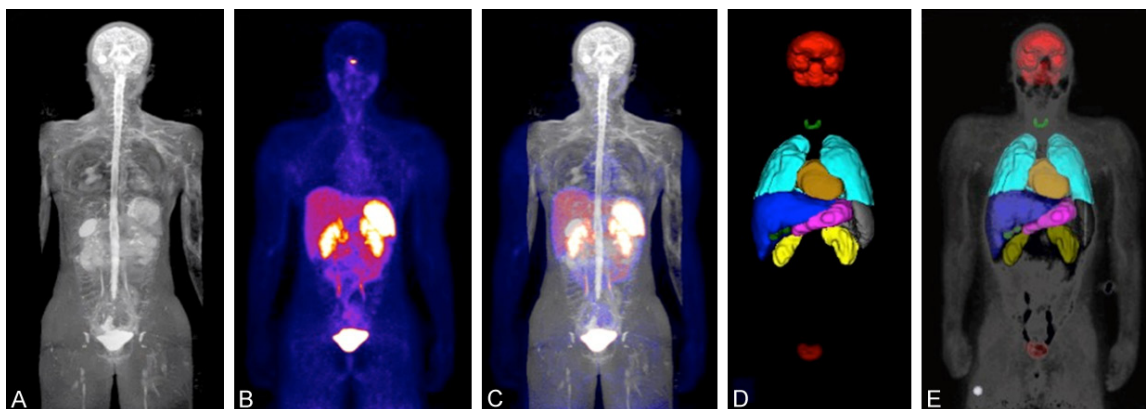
Representative maximum-intensity projection images of simultaneously acquired body MRI (A), ^{68}Ga -DOTATOC PET (B), overlaid PET/MRI (C), volume of interest analysis (D) and overlaid volume of interest on representative PET image (E).
